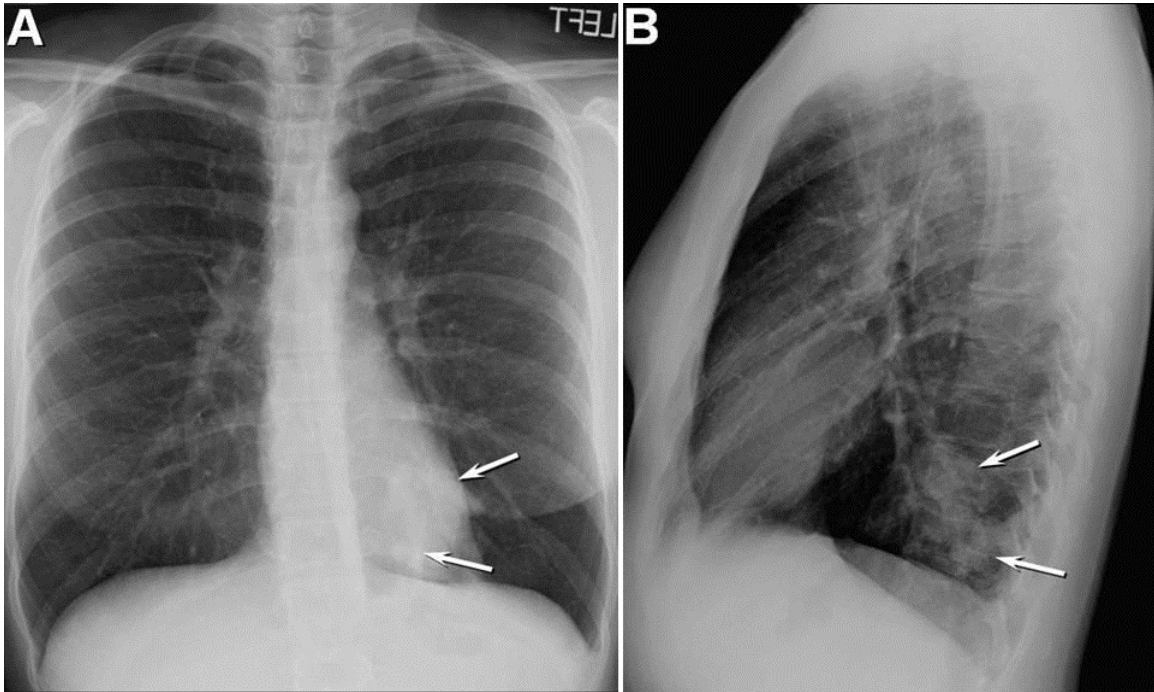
Chest radiography with abnormalities indicated by arrows.
